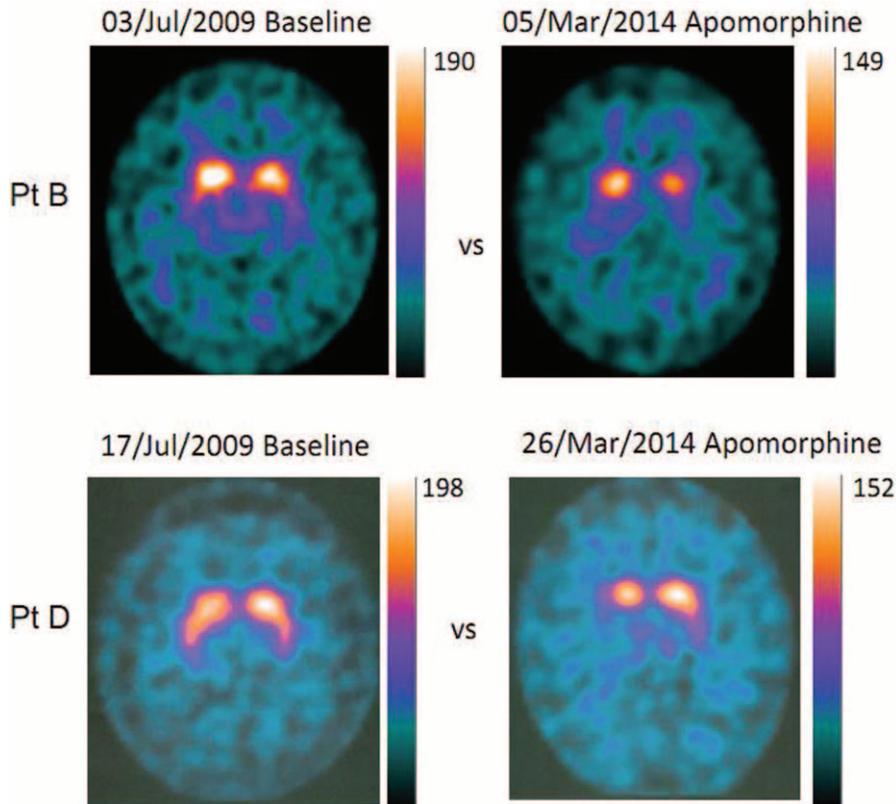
FP/CIT SPECT acquisition in two patients (PtB, PtD) chronically treated with apomorphine. Baseline SPECTs were acquired 6 years before, second acquisitions were obtained during chronic treatment. Notice that BP decay is in the range (Table 3) expected for the time lapsed from first acquisition, and the BP values are multiples of values (4–5 times) observed during AC (Figures 1 and 2). AC = akinetic crisis, BP = binding potential, SPECT = single-photon emission computerized tomography.
